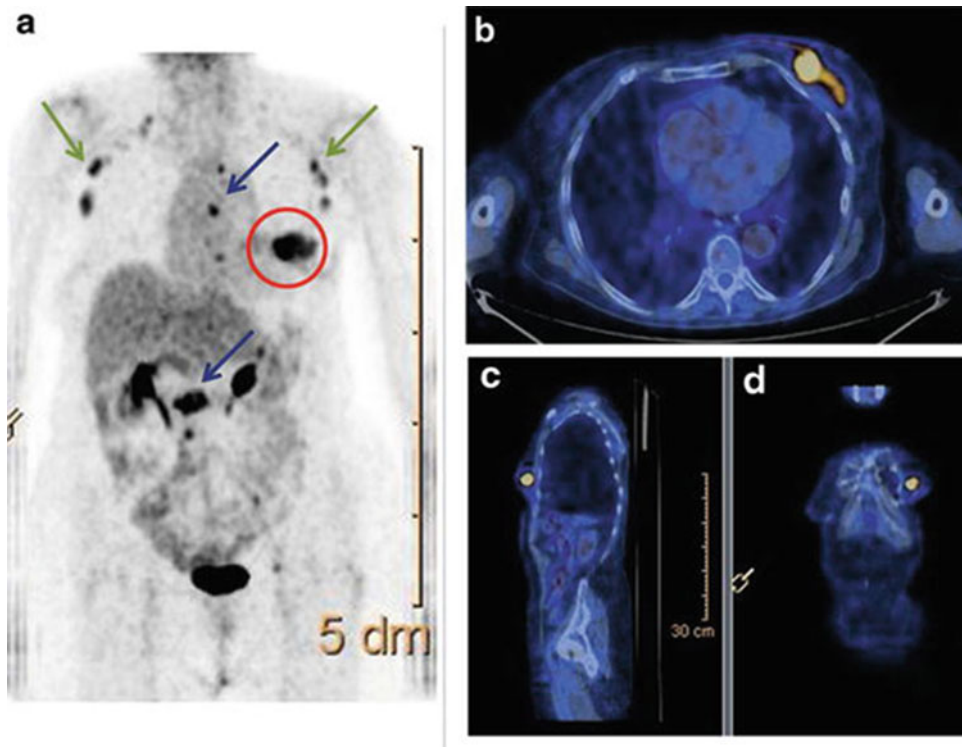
Maximum intensity projection (MIP) (a, red circle), axial (b), sagittal (c), and coronal fused PET/CT images of the [^{18}F]FDG-avid left breast lesion. The MIP
